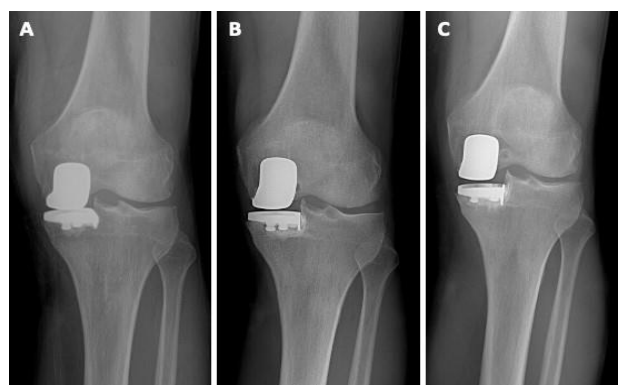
Standing anterior-posterior left knee radiographs of the patient described in Case 1. (A) Three weeks after primary medial UKA with well-fixed components. (B) Nine months postoperatively, the patient developed a radiolucent line beneath the tibial component suggestive of loosening. (C) Three weeks after revision of the tibial component with well-fixed components
